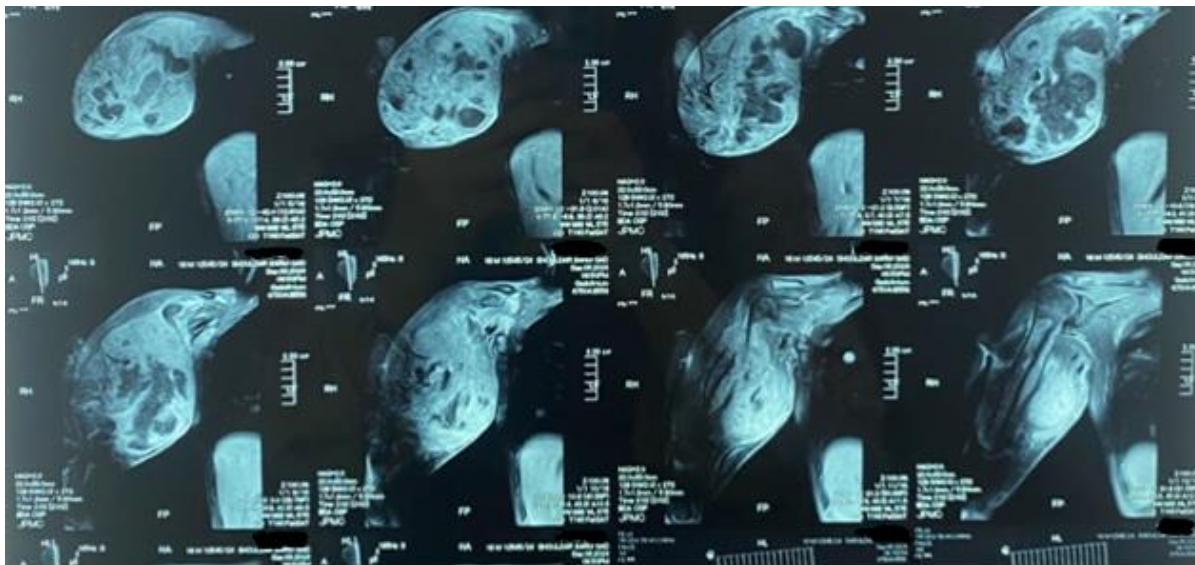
Magnetic resonance imaging of the affected region.
